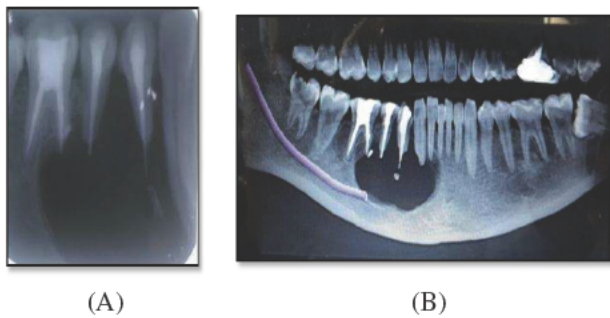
(A) Intraoral periapical radiograph revealed a well-defined unilocular radiolucency extending from the distal aspect of tooth #43 to mesial aspect of the mesial root of #46 periapically. (B) CBCT also revealed well defined unilocular radiolucency with peripheral smooth corticated border.
